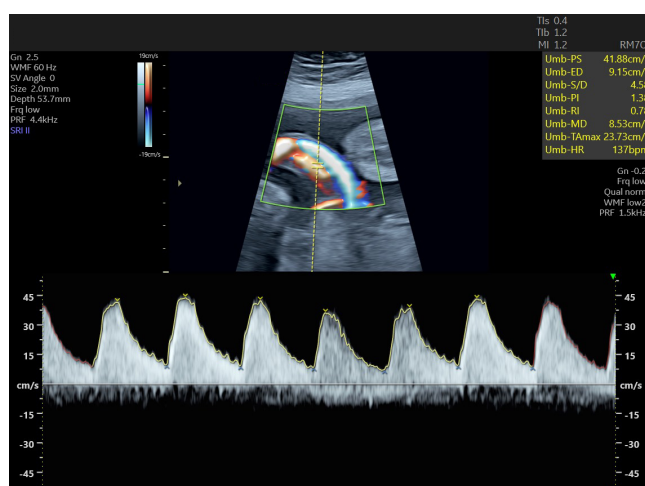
Doppler waveform from umbilical artery obtained transabdominally in third trimester.
